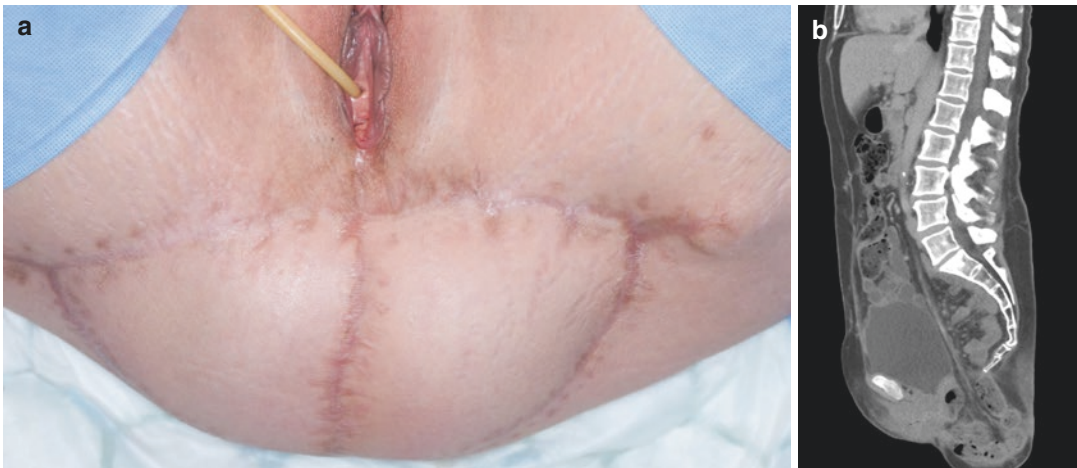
A picture of perineal hernia after APR despite previous gluteal fold flap reconstruction (a) and CT scan showing descent of small bowel into the deep pelvis (b), through the pelvic floor defect, sitting below the coccyx
